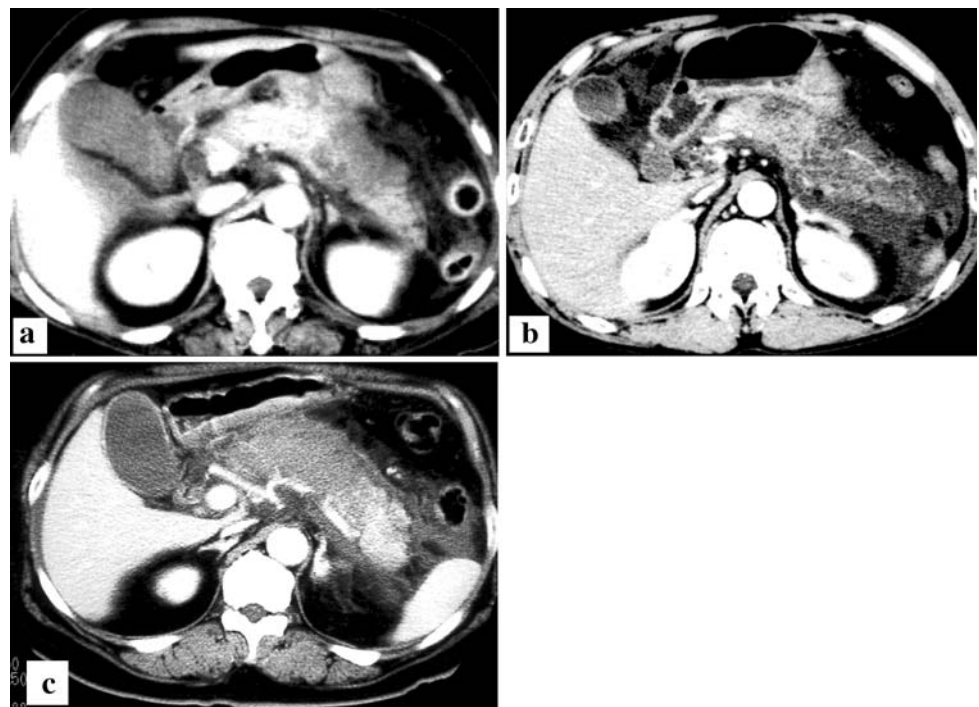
Extent of hypoenhanced lesion of the pancreas based on contrast-enhanced computed tomography (CT). a Hypoenhanced lesion is localized in the tail of the pancreas (0 point), b hypoenhanced lesion is localized in the entire tail and part of the body of the pancreas (1 point), c hypoenhanced lesion is localized in the entire gland, except for part of the tail of the pancreas (2 points)
